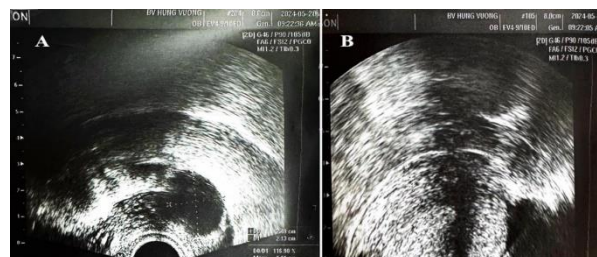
Transvaginal ultrasound images on 28 May 2024 demonstrating a dominant follicle measuring 23 mm (A) and an endometrial thickness of 10 mm with a persistent trilaminar pattern (B)
